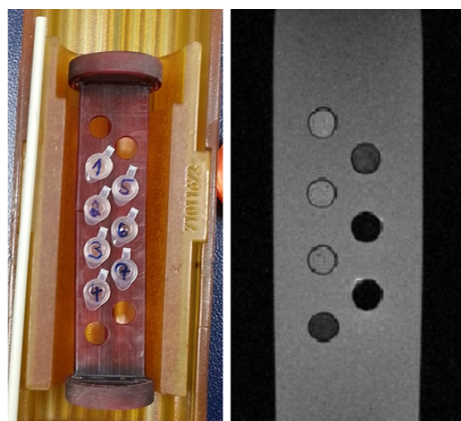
Sample holder with serial dilution of oleic acid coated MNP embedded in Permagel (left) and MRI multi-echo images (right; FOV = $80 \times 40 \text{ mm}^2$, TH = 1 mm, 4 averages, TR = 3 s, TE = 5 ms).
